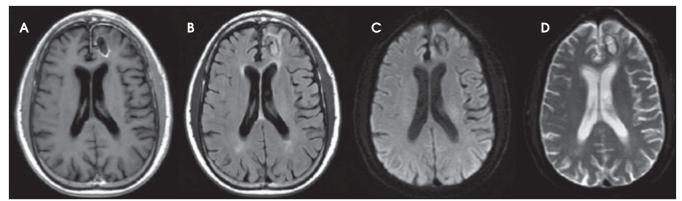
Axial MRI taken for a patient with a left frontal glioblastoma with four sequences, A) T1 post contrast, B) T2 FLAIR, C) DWI and D) ADC map. ADC was calculated using b0 and b1000 diffusion-weighted images. These studies demonstrate the qualitative differences between imaging sequences that can highlight enhancing gross tumor involvement seen in image A, surrounding edema in B, and diffusion restriction at the rim of the tumor cavity along with unrestricted diffusion in the cystic/necrotic tumor core seen in images C and D.
